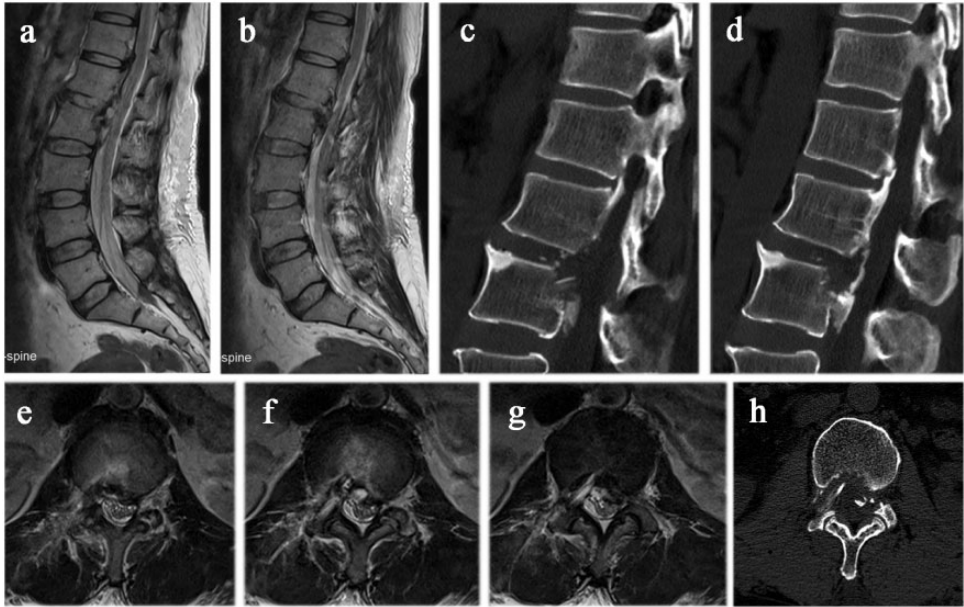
Postoperative (a, b) sagittal and (e–g) axial T2-weighted magnetic resonance images and (c, d) sagittal and (h) axial computed tomography images. (c) The decompression was sufficient, and the bony masses that had adhered to the dural sac were also removed. (g) The decompression range reached the opposite side. (d) Some residual bony masses that had been heavily adhered to the dural sac were treated with the “floating method” with no substantial oppression.
